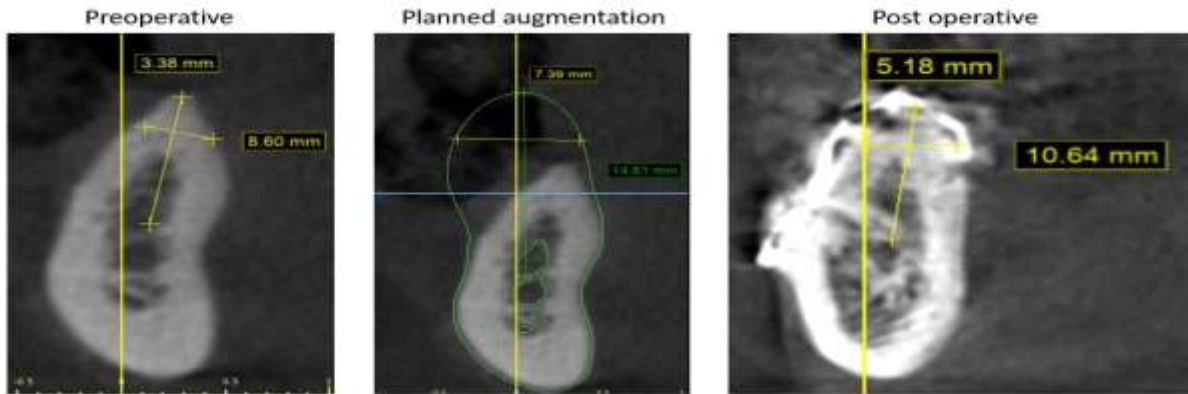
a) Coronal preoperative CBCT showing deficient alveolar height for lower right seven, b) Planned augmentation and green outline represent the stitched 3d planning of future augmentation, c) Six months postoperative coronal CBCT photo-radiograph showing increase height of ridge immediately before Ti-mesh removal and implant installation.
